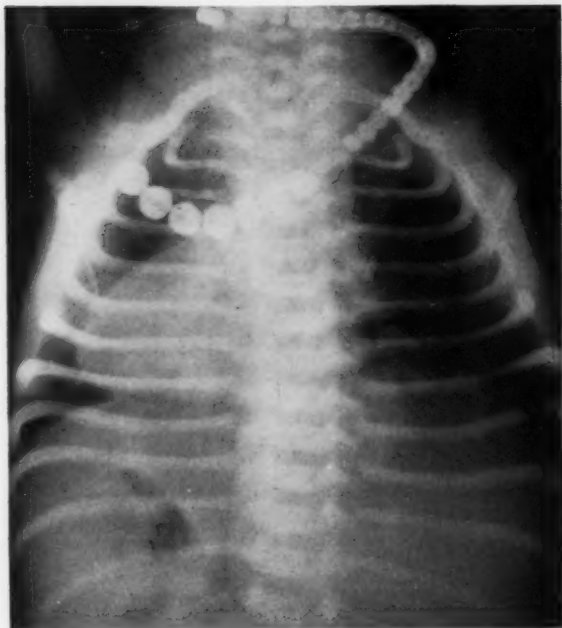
X-rays of Case 2 with small area of atelectasis involving the posterior portion of the right lobe, with no shift of the central shadows.
